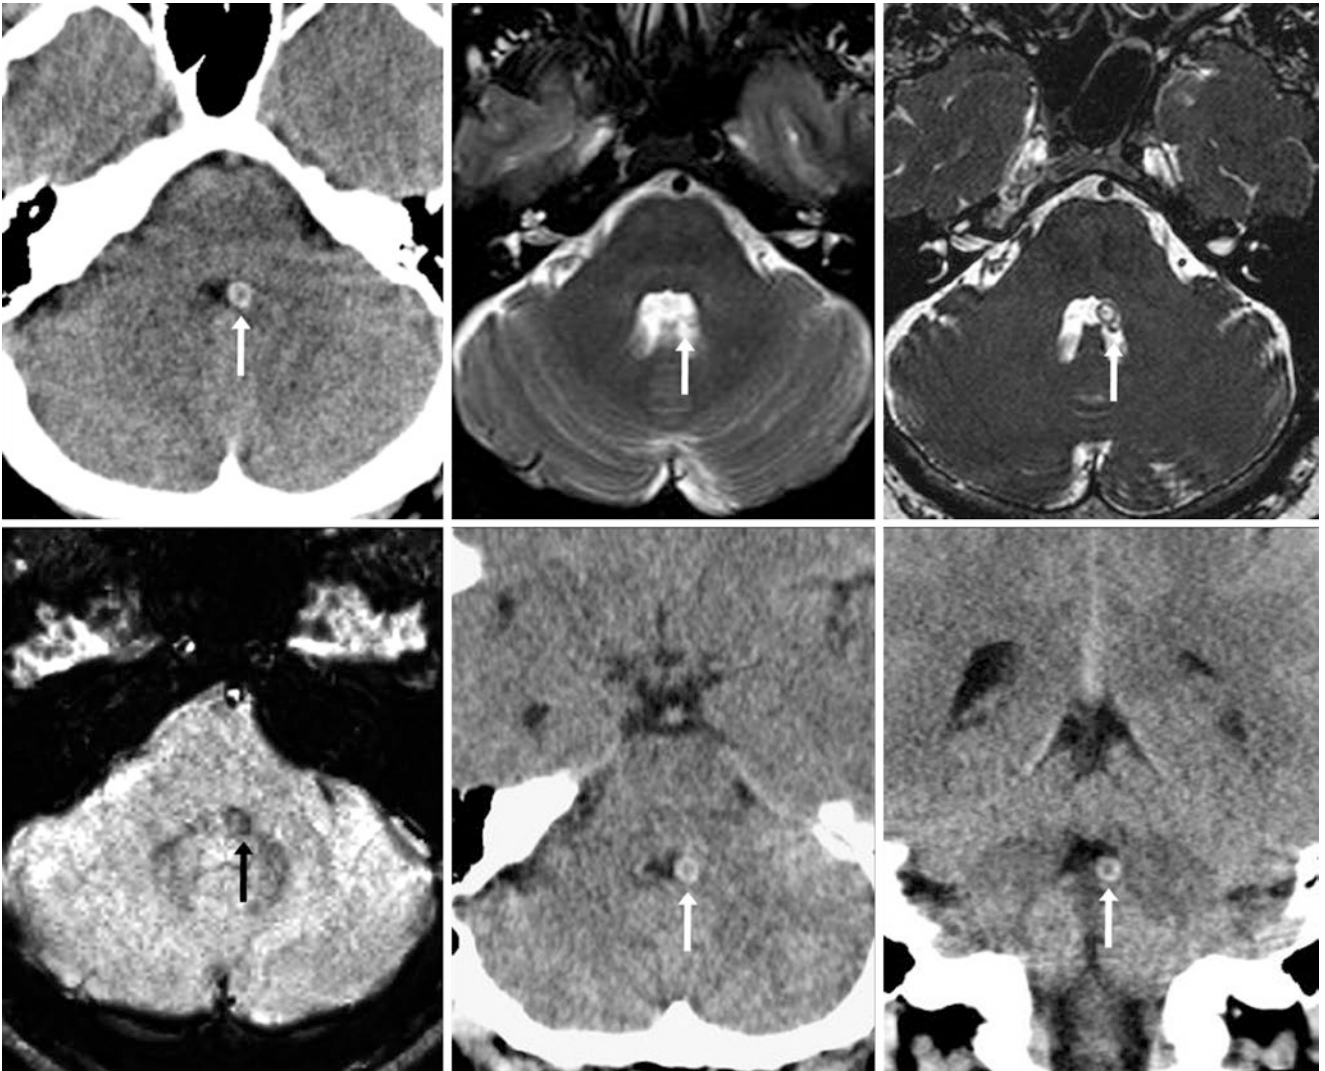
A 44-year-old patient with headaches and calcified CP (arrows) within the fourth ventricle on NECT (top left). On a 1.5 T MRI the CP is seen not on spin-echo T2WI (top middle) but is visualized on a balanced three-dimensional T2WI (top right), a sequence that accentuates CSF signal intensity. The CP produces focal susceptibility artifact
